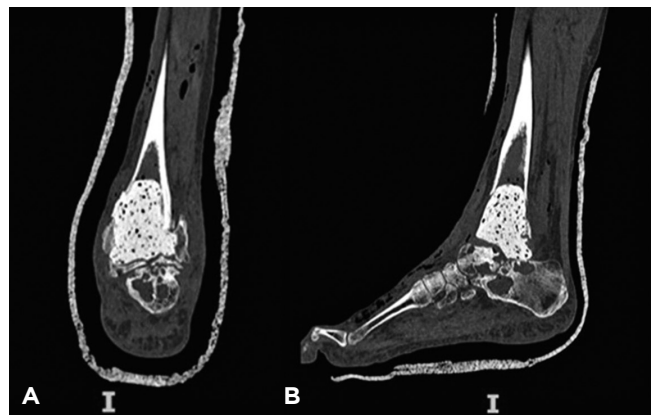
Computed tomography scans (A = Coronal and B = Sagittal) following the initial procedure demonstrating the cement spacer with large cysts in the residual talus and calcaneus, and the bony defect of the distal tibia.
